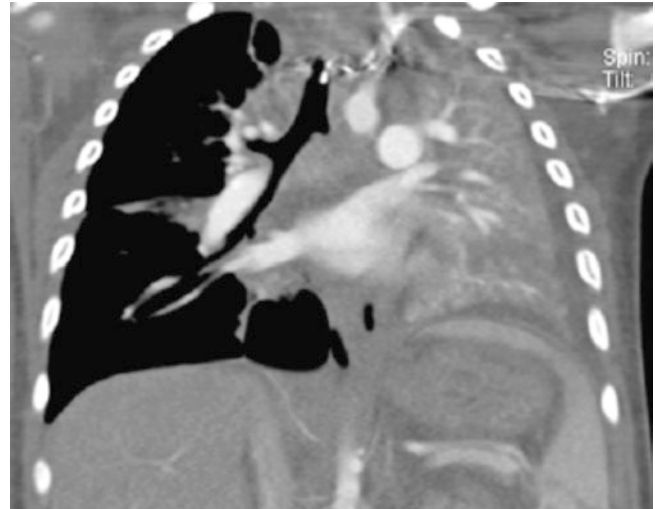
Young children with cast bronchitis. Enhanced coronal CT image confirmed a complete obstruction of the proximal left main bronchus, but did not show the exact nature of the obstructing process
